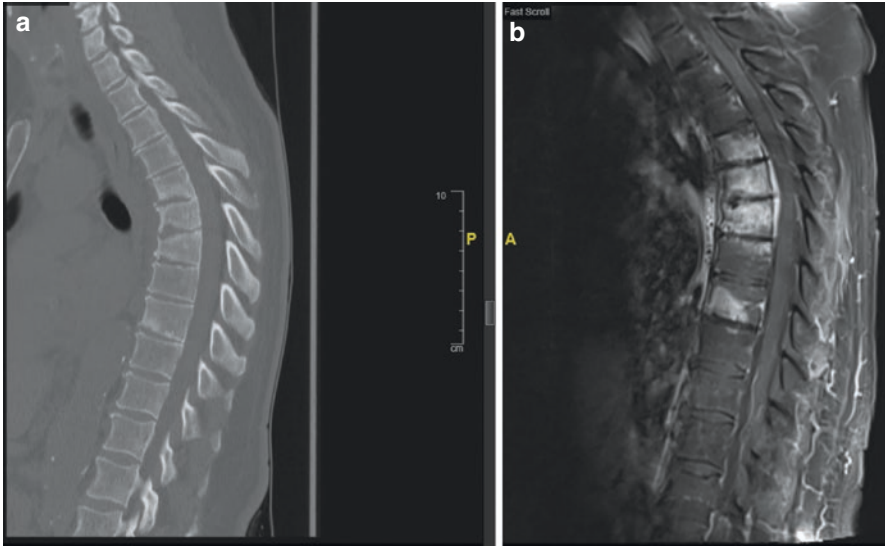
(a) CT and (b) MRI T1-weighted of a rheumatoid arthritis patient on bDMARDs with spinal TB affecting thoracic spine T5-T9
